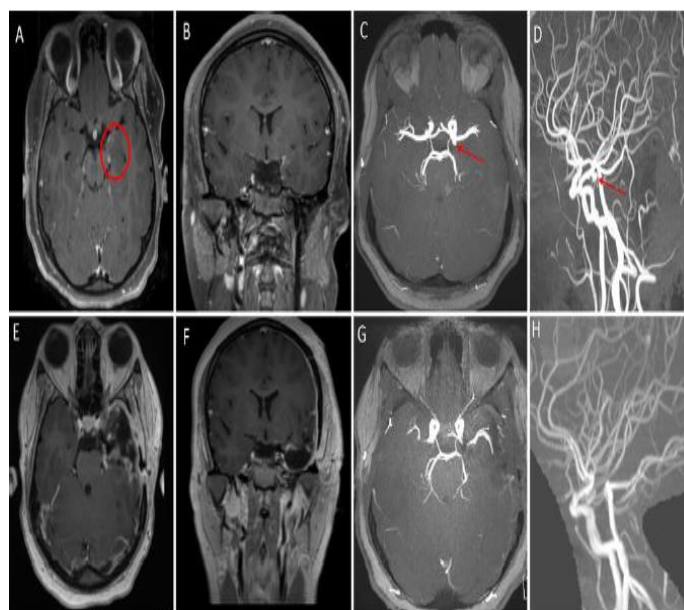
A left anteromesial temporal lesion with subtle contrast enhancement along the medial and superomesial uncus is shown on preoperative axial (A) and coronal (B) T1-weighted, contrast-enhanced magnetic resonance (MR) images. A 4-mm left AChA aneurysm is shown on preoperative axial (C) and sagittal three-dimensional (3D) reconstruction (D) MRA images. Axial (E), coronal (F), and sagittal (3D reconstruction) T1-weighted, contrast-enhanced MR images taken three weeks after a left craniotomy for lesion excision and clip ligation of a left AChA aneurysm are shown.
